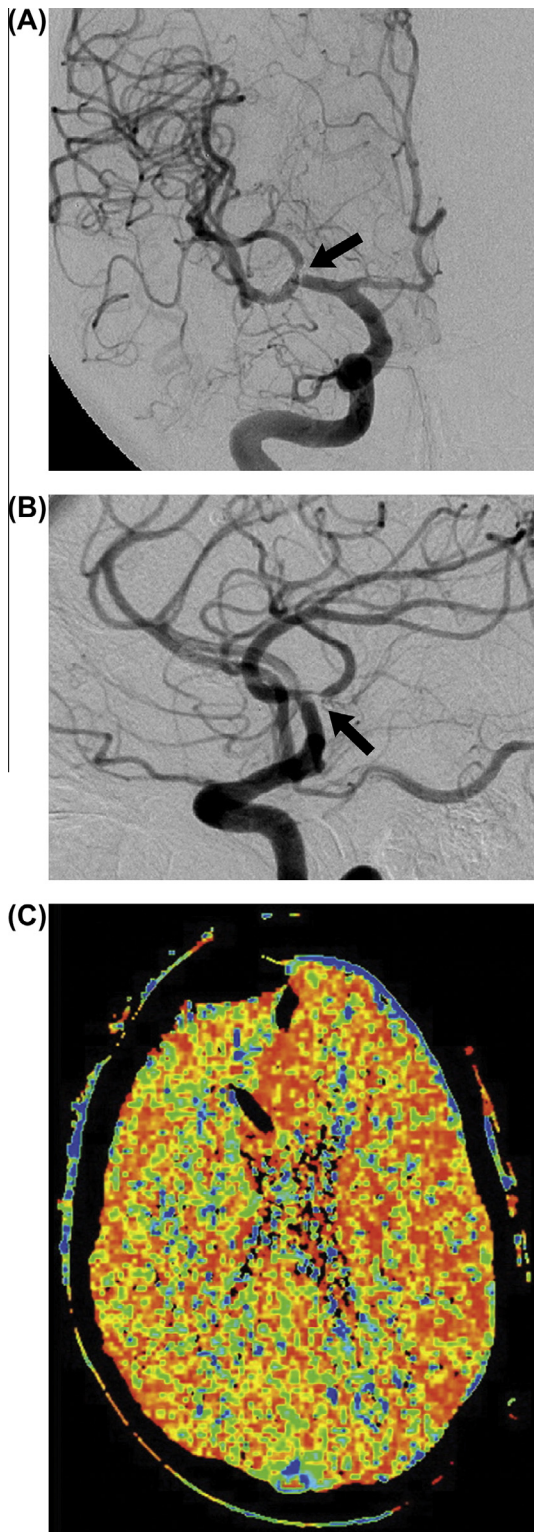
(A) Postoperative anteroposterior and (B) lateral right internal carotid artery angiography demonstrated severe stenosis of the smaller branch (arrows). The patient subsequently developed a left pronator drift and axial CT perfusion scan (C) showed cerebral hypoperfusion on the right. Used with permission from Barrow Neurological Institute.
